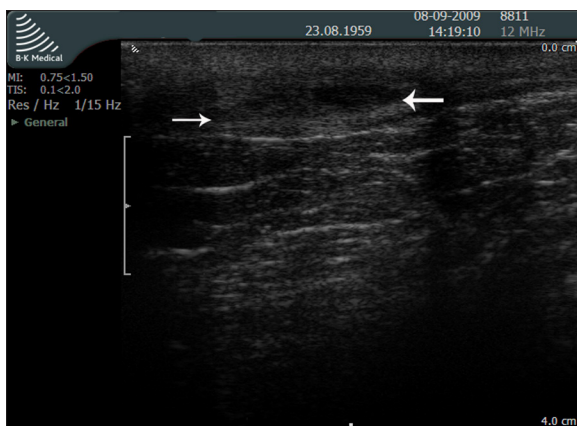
Transperineal ultrasound: fluid-solid lesion within the subcutaneous tissue of the perianal area, which had developed within the course of HS (between arrows)
